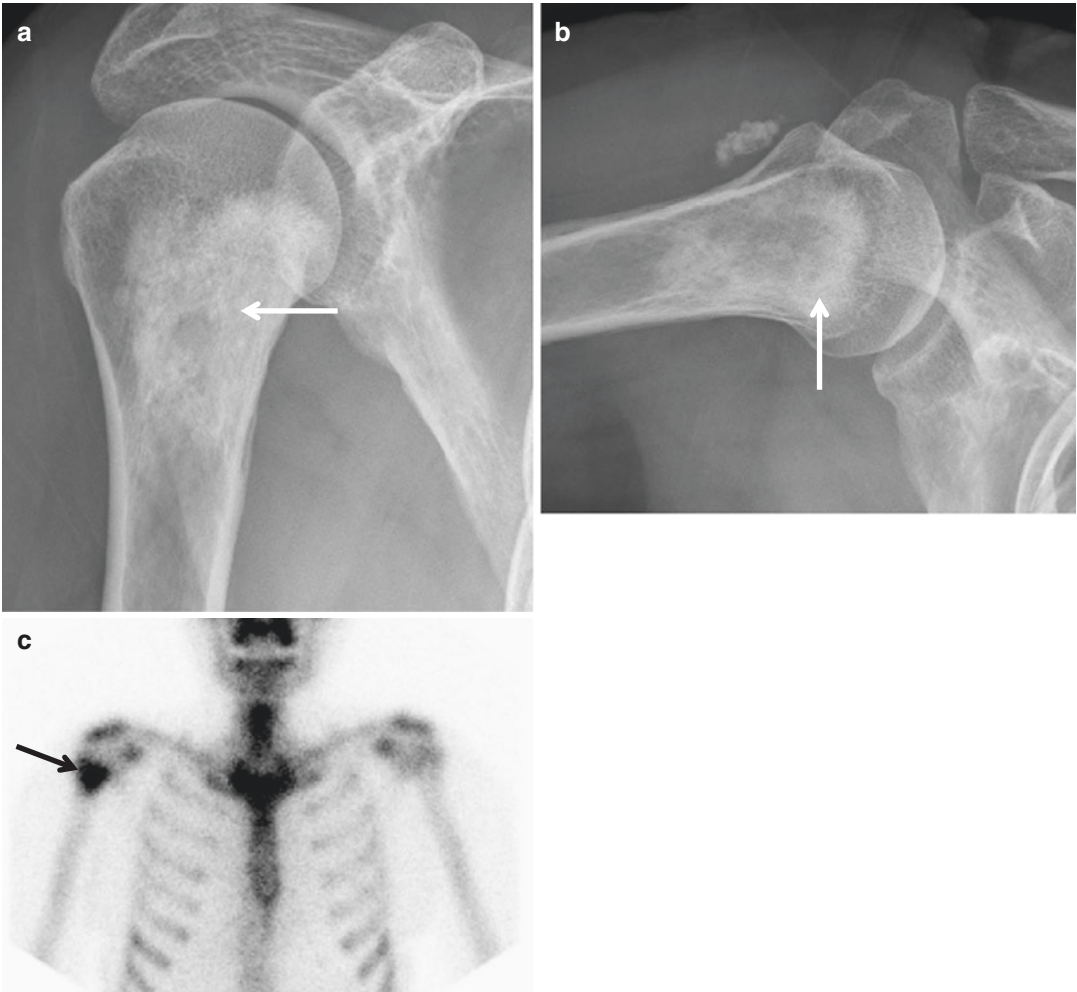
Low-grade osteosarcoma. (a) Anteroposterior radiograph of the right humerus shows an osteolytic lesion with sclerotic rim, internal trabeculation, and areas of osteoid matrix (*arrow*). (b) Lateral view again shows an osteolytic lesion with sclerotic rim, internal trabeculation, and areas of osteoid matrix (*arrow*). (c) Bone scan shows increased uptake (*arrow*) in the right proximal humerus. (d) Sagittal T1-weighted MR image shows focal low signal intensity (*arrow*) with adjacent areas of intermediate
